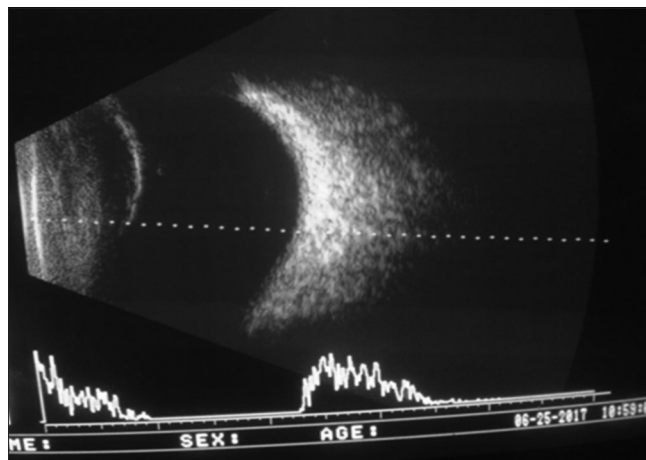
Sonogram of a 52-year-old male demonstrating cataract with vitreous changes
